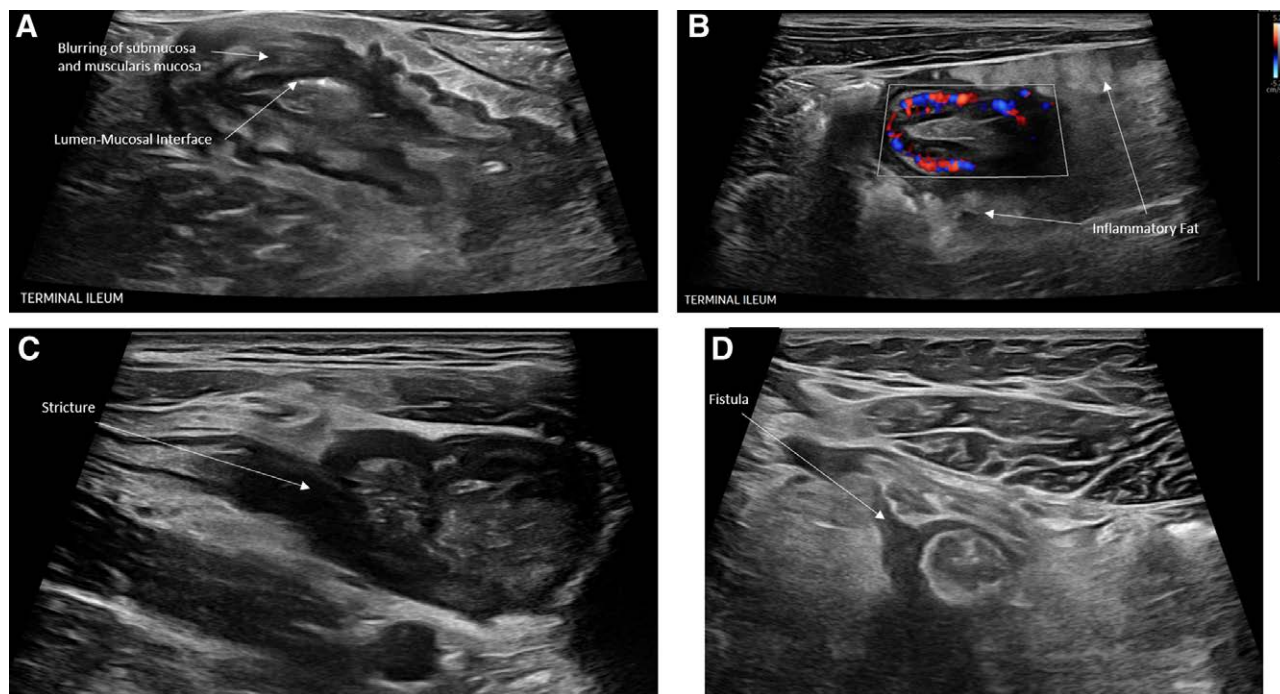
(A) Ultrasound still frame showing loss of bowel wall stratification shown in the terminal ileum with disruption between the bowel layers in a thickened terminal ileum. (B) Ultrasound still frame displaying increased color Doppler signal representing increased bowel wall hyperemia in the terminal ileum encased in surrounding hyperechoic inflammatory fat. (C) Ultrasound still frame highlighting inflamed terminal ileum with a stricture characterized by luminal narrowing and proximal bowel dilation. (D) Ultrasound still frame highlighting a fistula tract from an inflamed terminal ileum leading to an intraabdominal wall abscess.
